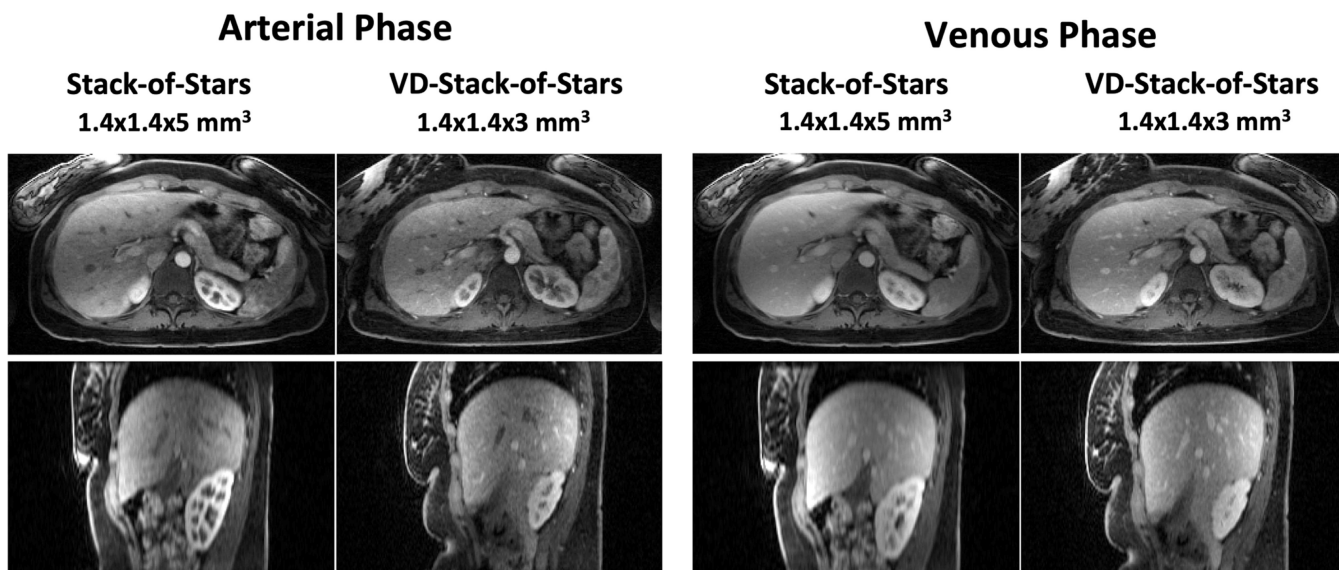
Comparison of liver DCE-MR images acquired using both stack-of-stars and VD-stack-of-stars sampling and reconstructed with respiratory-weighted GRASP in another subject for both axial and sagittal planes. Same as in Figure 6, VD-stack-of-stars sampling achieved increased image sharpness and vessel clarity in both arterial and venous phases, particularly in the reformatted sagittal plane.
